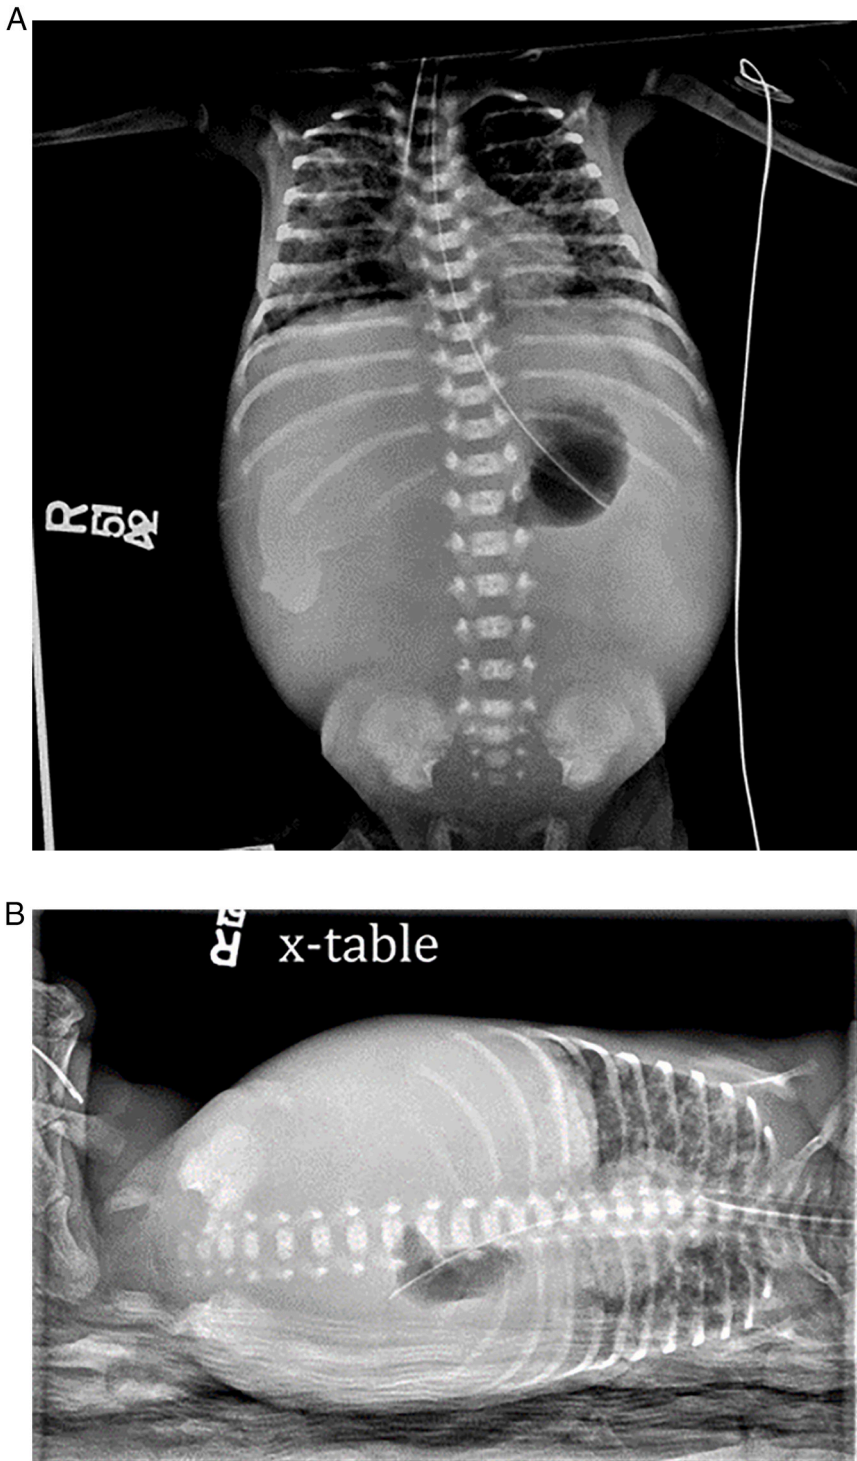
A. AP X-ray view of patient on the day of operation, prior to paracentesis and operative intervention. The X-ray demonstrates a gasless abdomen with no free air noted. B. Cross table X-ray view on the day of operation, prior to paracentesis and operative intervention with similar findings of gasless abdomen again with no free air noted.
